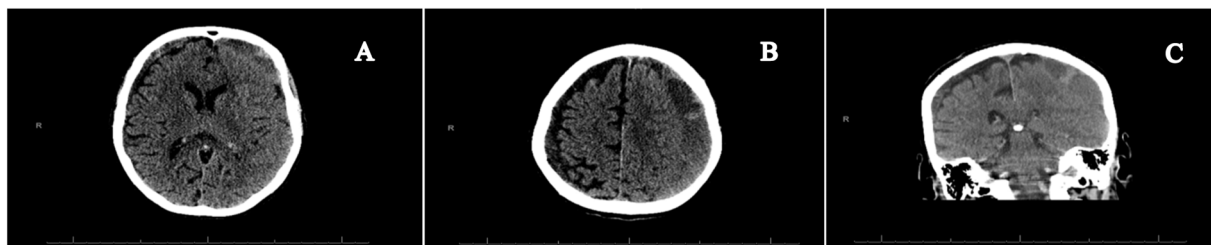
A and B are coronal sections of patient's brain CT showing subdural hematoma. C shows a sagittal section of brain CT showing right and left subdural hematoma.
